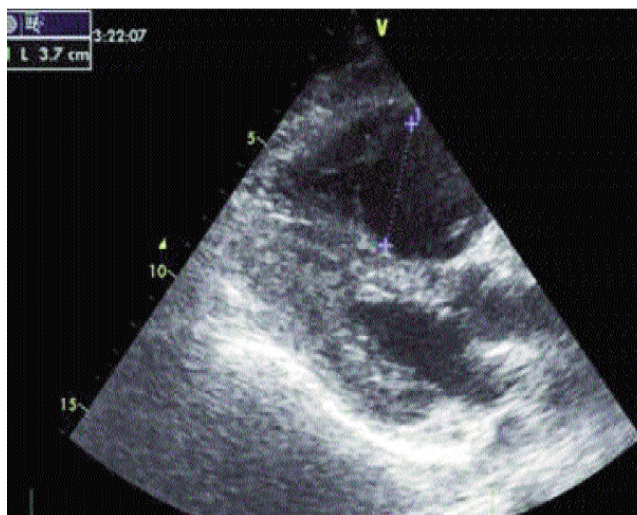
2D transthoracic echocardiogram in long axis parasternal view, size of RV measured pre-thrombolysis is 37mm.
